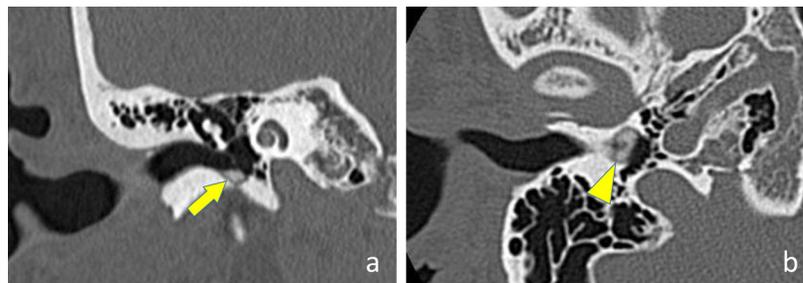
Computed tomography of the right temporal bone. a,b: CT reveals a mass with calcification at the external auditory canal in contact with the tympanic membrane.
